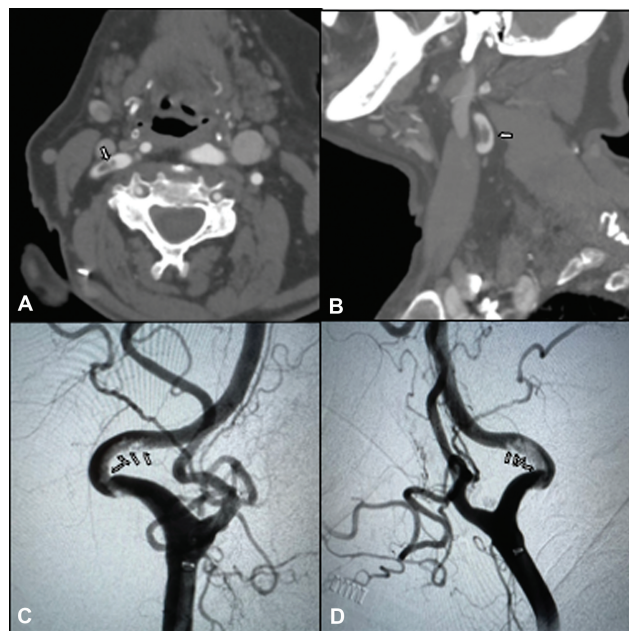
(A) Axial and sagittal (B) computed tomography angiography view of a carotid free-floating thrombus (white arrows) demonstrating a typical cross-sectional donut sign. (C) Anteroposterior and lateral (D) angiography views of the floating thrombus in the internal carotid artery (white arrows).
